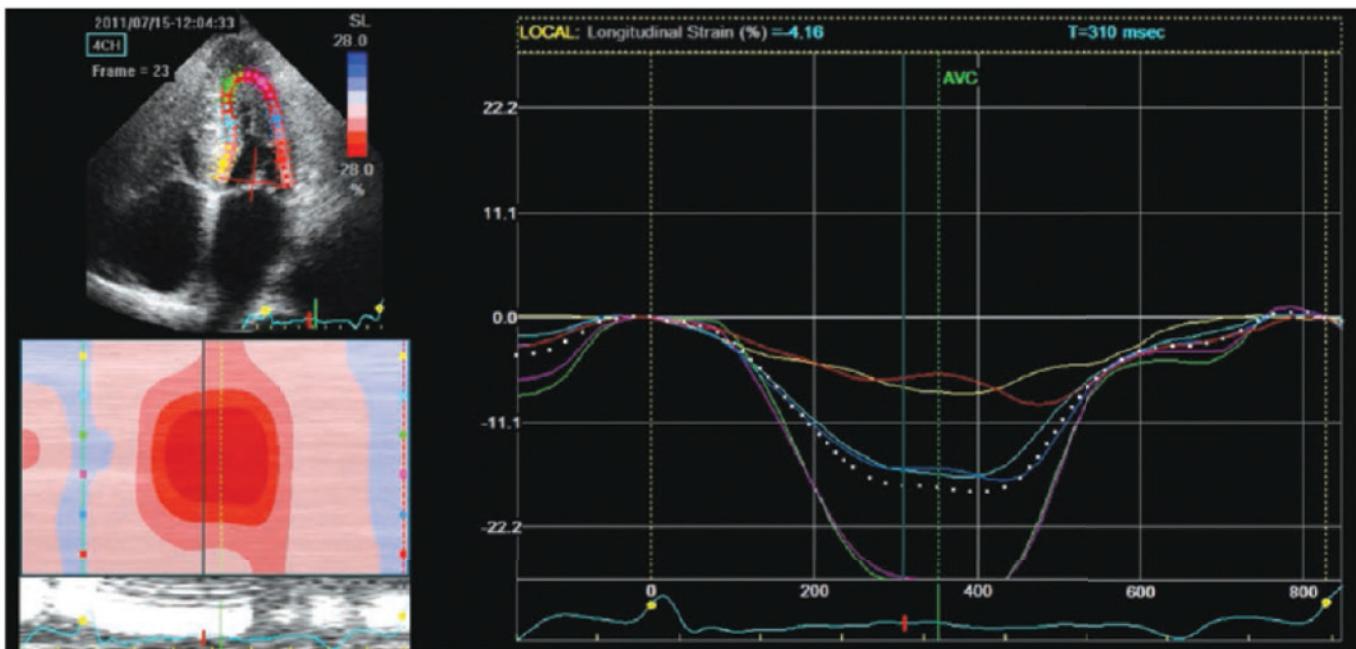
Echocardiographic strain imaging in amyloid cardiomyopathy. The “bulls-eye” appearance of the longitudinal strain pattern from an echocardiographic apical four-chamber view is shown in a patient with familial amyloid cardiomyopathy and a normal ejection fraction. The appearance represents a gradient of longitudinal strain from the apex to the base with relatively well-preserved apical strain and severely impaired basal strain. In contrast, normal subjects have no significant strain gradient from the apex to the base. This appearance, a useful diagnostic finding, is seen in more than 80% of patients with cardiac amyloidosis, regardless of the precursor amyloid protein.
